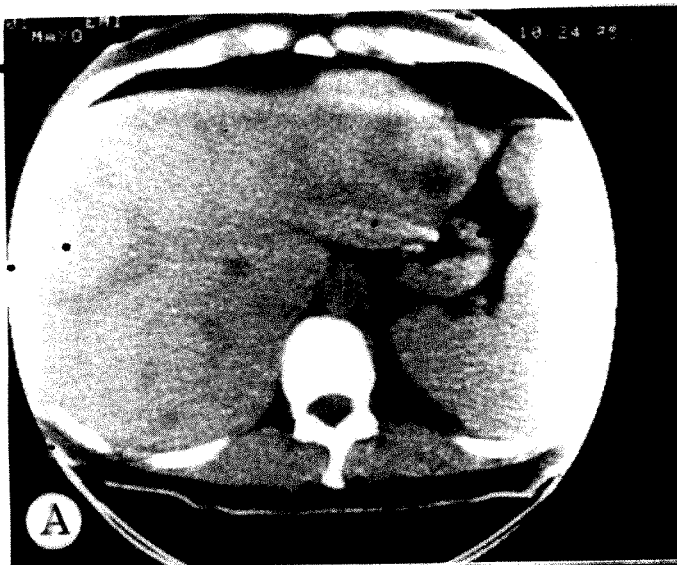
21-year-old man with recurrent fever, large area of low uptake on technetium liver scan, and increased uptake on gallium scan. A and B, CT scans showing large low density lesion with indistinct margins in right lobe of liver. Hepatic abscess drained at operation.
